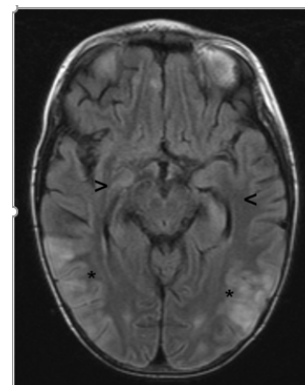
MRI patient 2 four weeks after diagnosis. Both hippocampal regions show alterations resembling posttransplant acute limbic encephalitis (PALE) (arrows).
